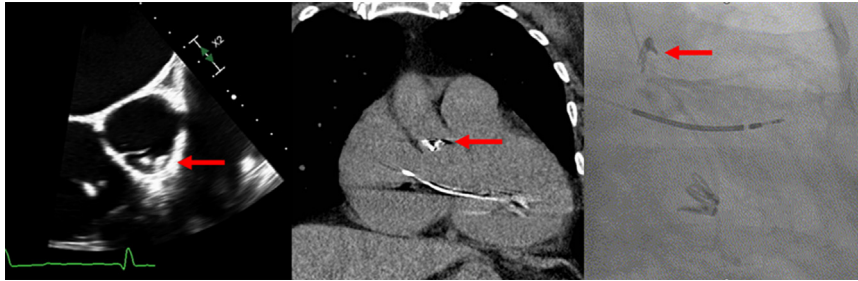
Echo, CT, and cardiac catheterization images demonstrating the MitraClip embolized to the RCA ostium. The embolized device is indicated by the red arrow.
